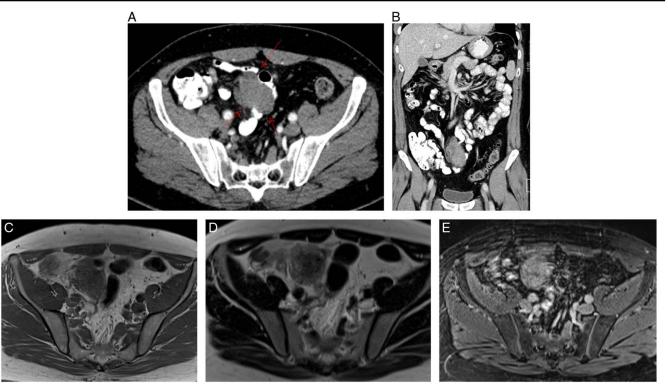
Postcontrast computed tomography axial (a) and coronal (b) images show a mesenteric soft tissue attenuation mass lesion with lobulated outlines displacing the bowel loops measuring $5.5 \times 3.5 \times 4.5$ cm in maximum dimensions. MRI axial T1 (c), T2 (d), and postcontrast VIBE (e) show intermediate signal intensity of the lesion in T1 and T2 sequences with mild postcontrast enhancement. VIBE, volumetric interpolated breath-hold examination.
